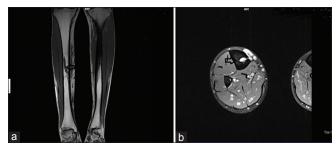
(a) Magnetic resonance imaging (MRI) leg showing complete tract of intratibial dilated perforator including its entry and exit point as well as external varices. (b) MRI leg showing complete tract of intratibial perforating vein including its entry and exit point as well as external varices.
